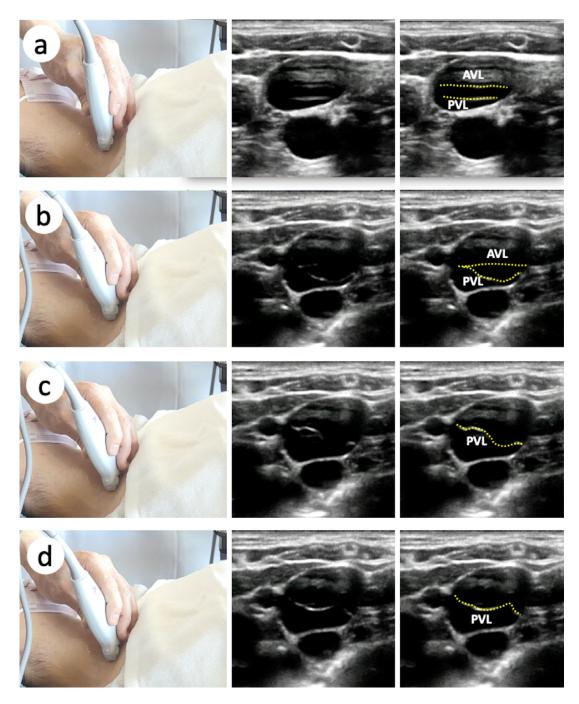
Ultrasound image of a normal internal jugular vein valve. The figures on the left show the locations of the ultrasound probes. The center figures are the ultrasound images. The figures on the right show the edges of the venous valves with yellow dashed lines. (a) Short-axis ultrasound view of the internal jugular vein at the midpoint of Sedillot's triangle. (b) Short-axis view at slightly caudal to the midpoint. (c) Short-axis view of the cephalic side of the clavicle. The anterior valve leaflets are indistinct. (d) Short-axis view immediately behind the clavicle. The anterior valve leaflets are indistinct. AML, anterior valve leaflet; PVL, posterior valve leaflet.
